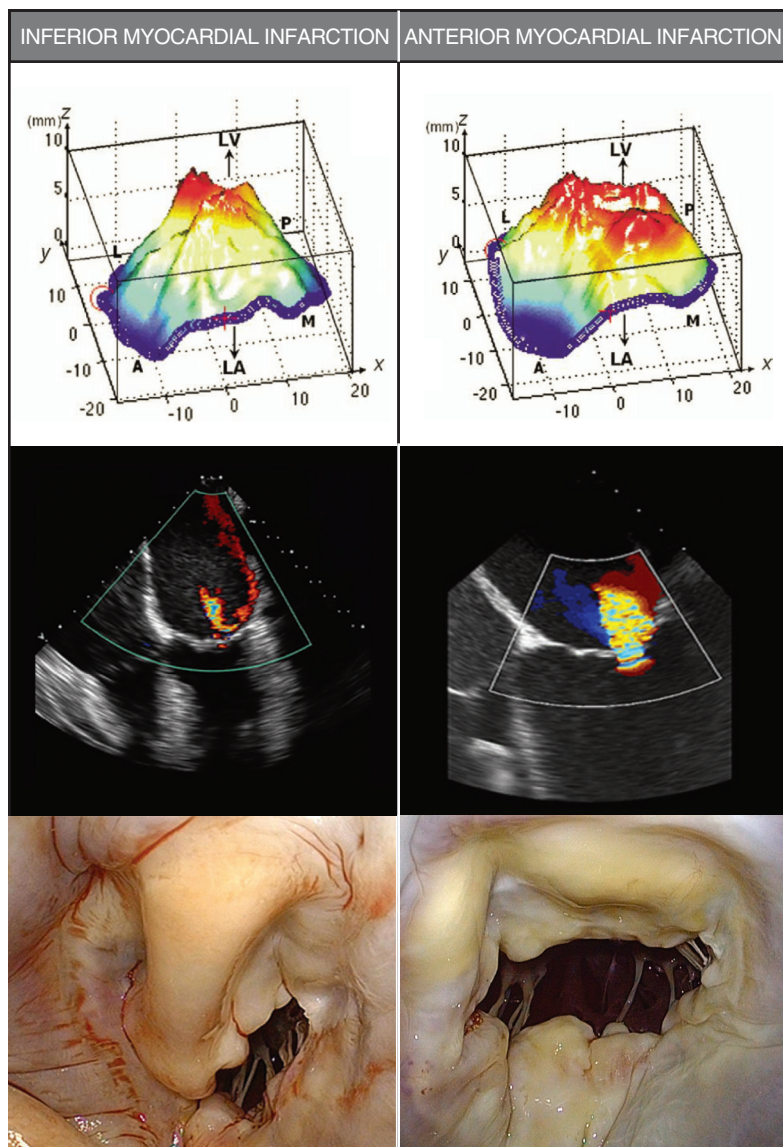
■ Tenting and tethering of mitral leaflets into the left ventricle (LV) in patients with ischemic mitral regurgitation. Areas of greatest displacement are shown in *red*. For patients with inferior infarction, tenting of leaflet is more localized with less bulging. For patients with anterior infarction, mitral valve leaflets are widely tethered and bulge toward the LV. The tethered leaflet area is smaller in inferior than in anterior myocardial infarction. A, Anterior; L, lateral; LA, left atrium; M, medial; P, posterior. (Top panels adapted with permission from Watanabe N, Ogasawara Y, Yamaura Y, et al: Geometric differences of the mitral valve tenting between anterior and inferior myocardial infarction with significant ischemic mitral regurgitation: quantitation by novel software system with transthoracic real-time three-dimensional echocardiography. *J Am Soc Echocardiogr* 19:71–75, 2006.)
